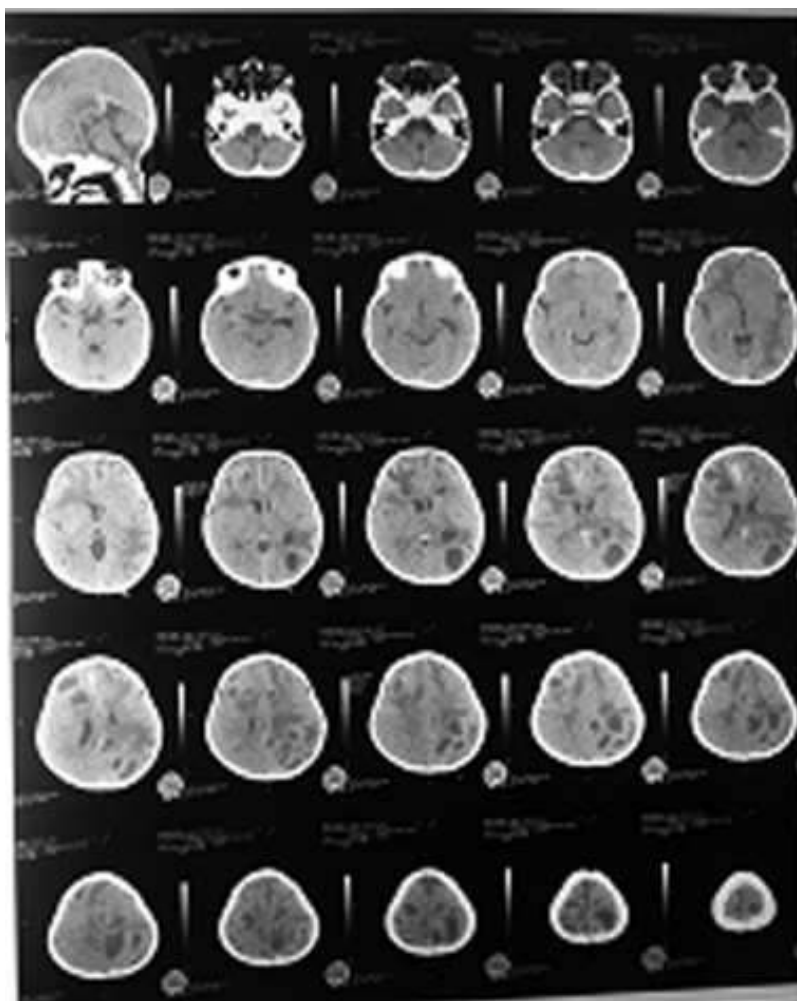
The head CT-scan result of the patient.
